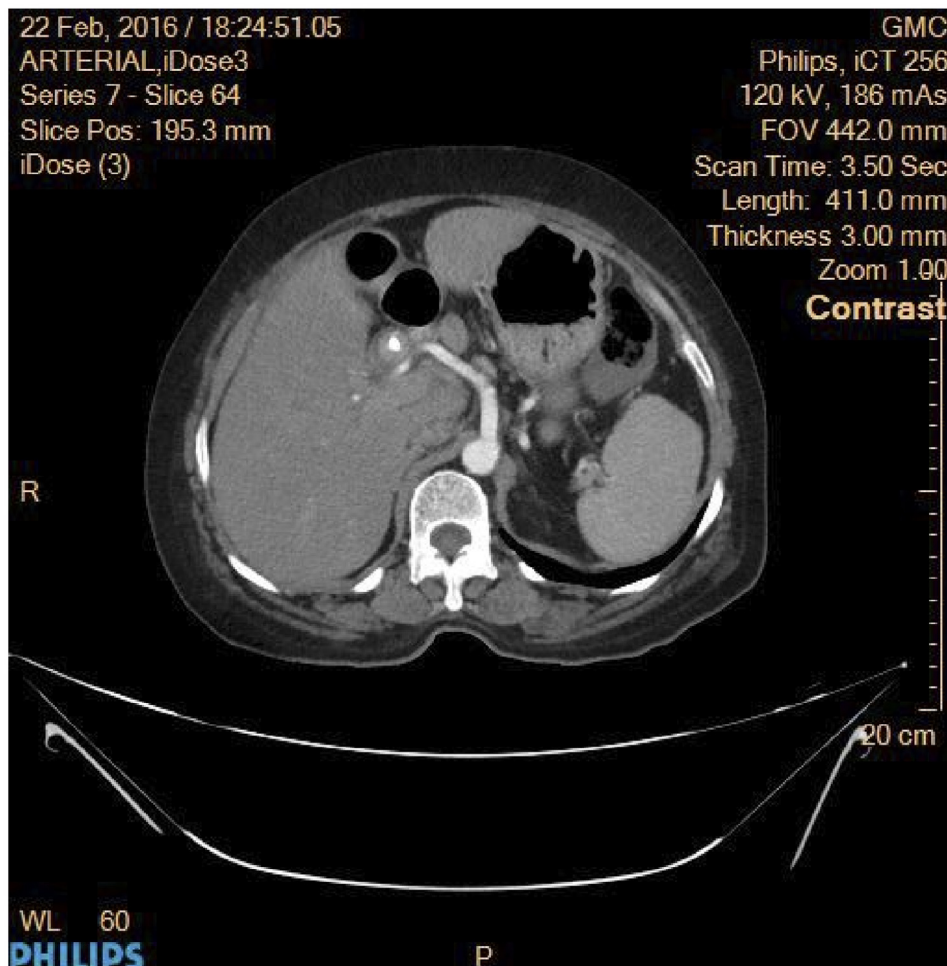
CT image of stent.
